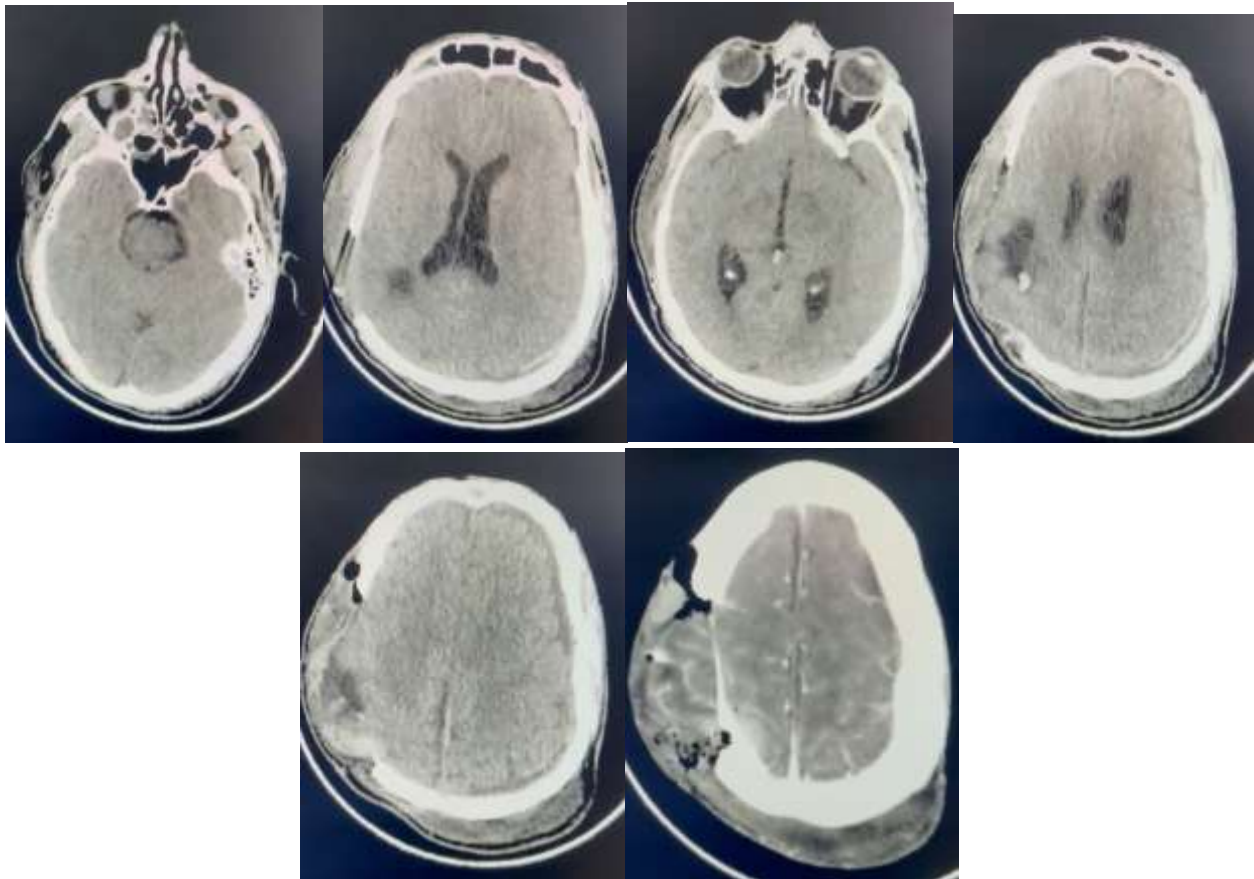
Control brain CT on day 4 showing marked regression of the right fronto-parietal subdural collection, stable right fronto-parietal intraparenchymal collection, resolution of subfalcine herniation, partial decompression of the right lateral ventricle with contralateral exclusion hydrocephalus, stable left parietal collection, and postoperative changes including a fronto-parieto-temporal bone defect with cerebral herniation.
